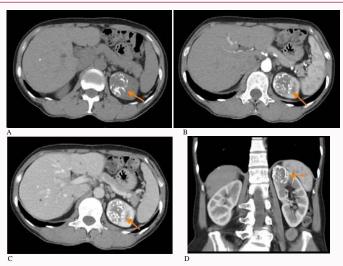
CT image of our cases: (A) Pre-contrast CT showed heterogenous renal tumor with calcification over upper pole (B) Arterial phase (C) Venous phase (D) Coronal view.
